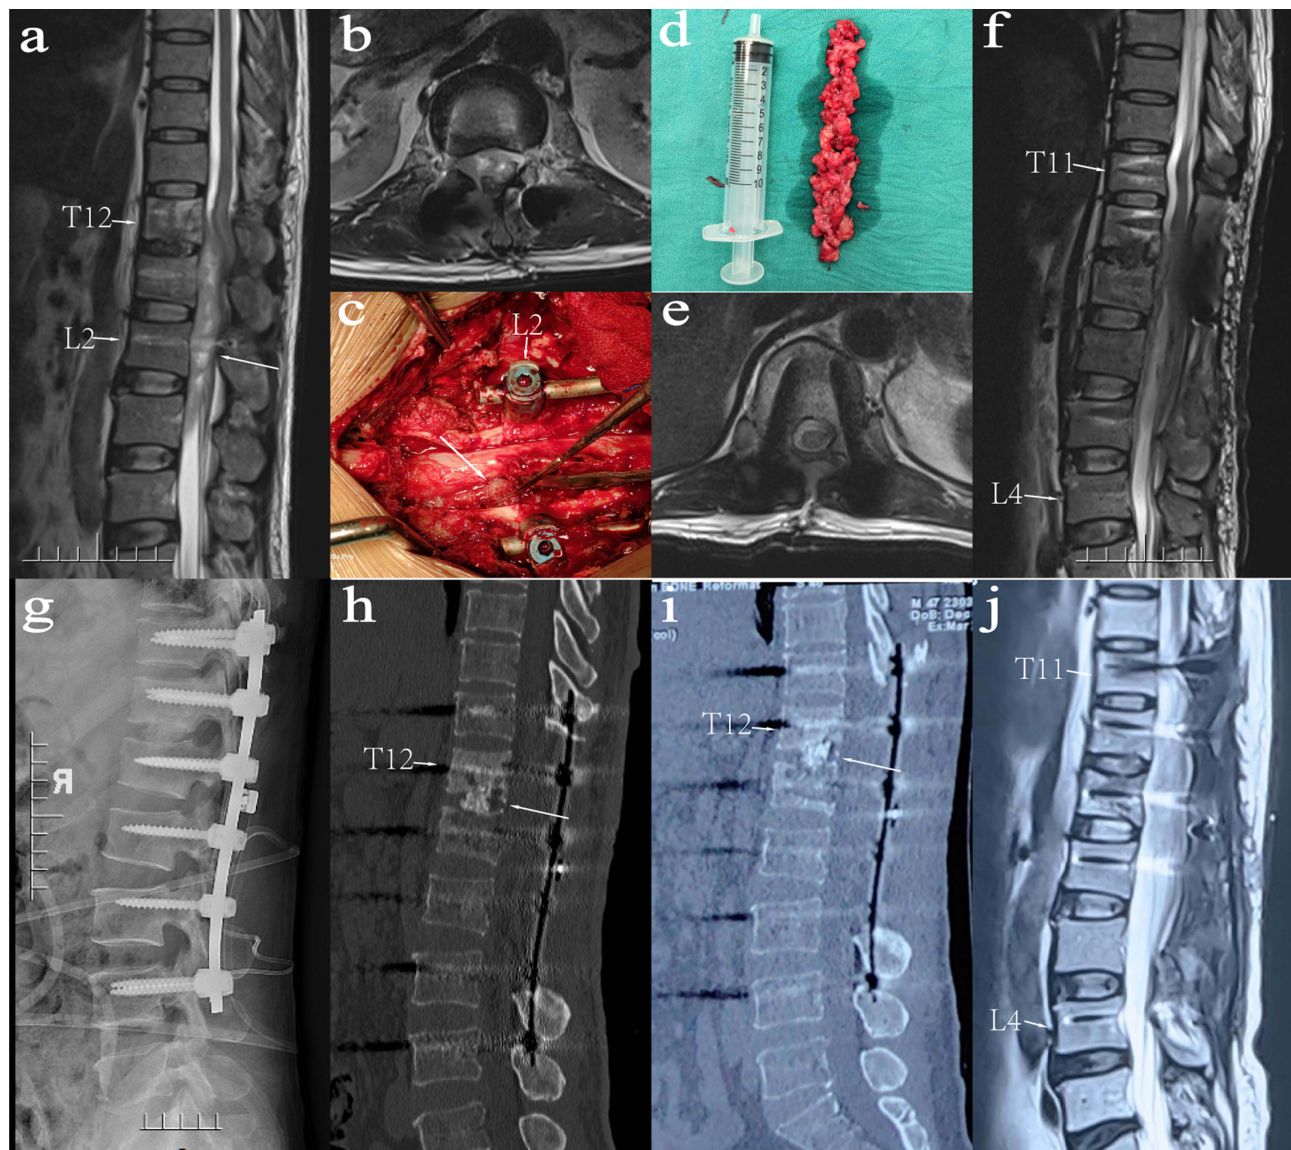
The second surgery and follow-up data. (a and b). Lumbar MRI before the second operation (October 8, 2022) showed fusiform abnormal signal lesions at the posterior of the T12-L4 vertebral body, spinal canal stenosis and spinal cord compression at the corresponding level. (c). During the second operation, a large amount of granulation tissue on the ventral side of the dural sac was found to be proliferated and elevated, compressing the dural sac with serious adhesion. (d). Granulation tissue and necrotic lesion tissue removed during operation. (e and f). Postoperative lumbar MRI (October 28, 2022) showed that the lesions posterior to T12-L4 were cleared, and the spinal cord compression was significantly relieved. (g and h). Postoperative lumbar X-ray and CT showed that the internal fixation position from T11 to L4 was good. (i and j). Half a year after operation, lumbar CT and MRI (March 20, 2023) showed that there was no breakage or loosening of T11-L4 internal fixation, no obvious compression of the posterior spinal cord, and T12/L1 bone graft fusion.
